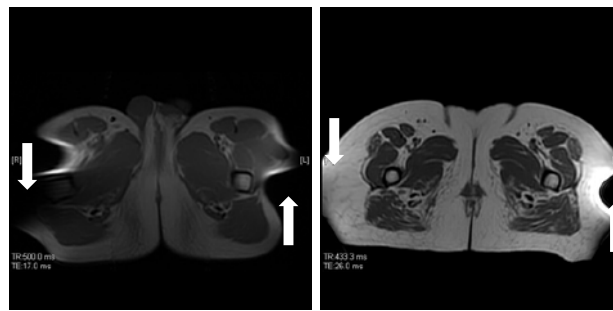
MR images of proximal femur (left) and distal pelvis (right). White arrows show the areas of geometry distortion.
